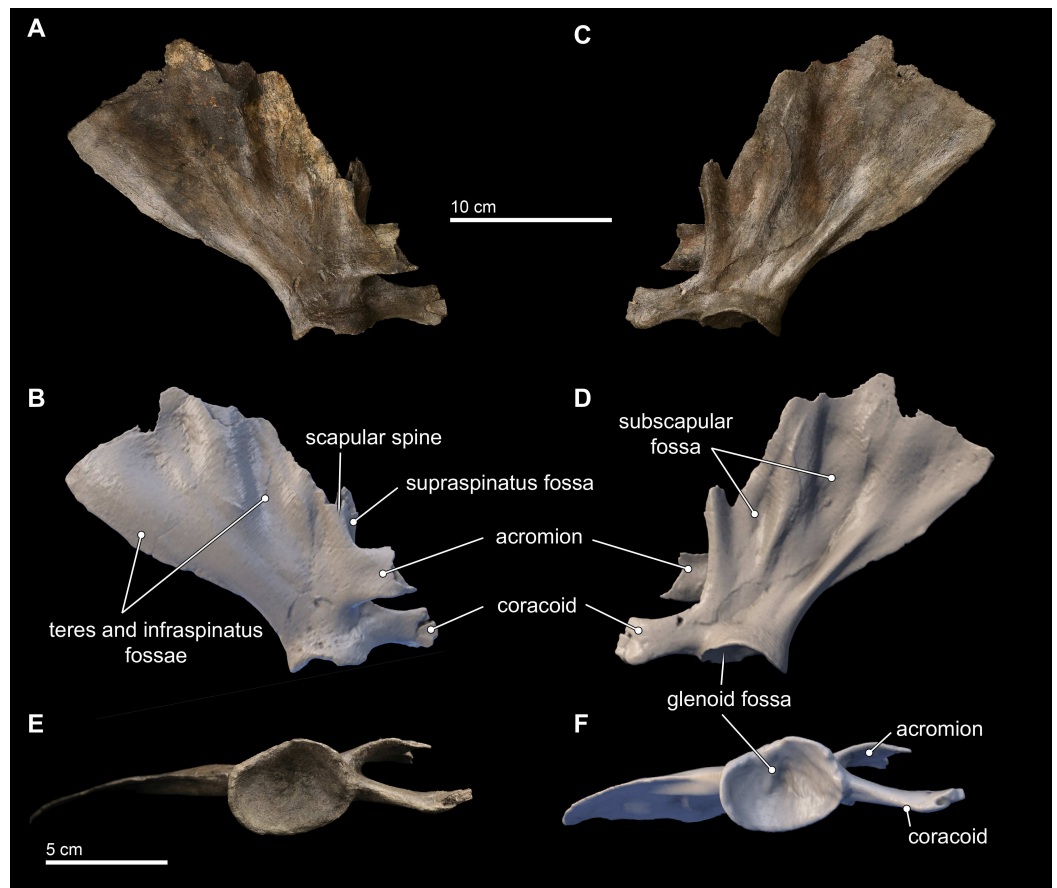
Scapula in lateral, medial, and distal views. Right scapula from *Isthminia panamensis* (USNM 546125) in lateral (A–B), medial (C–D), and distal (E–F) views. Each respective paired view shows photographs alongside orthogonal digital three-dimensional polygon model prepared from CT data, with lighting and color modifications using the Smithsonian X 3D browser. See <http://3d.si.edu/explorer?s=dmsTMI> (lateral view), <http://3d.si.edu/explorer?s=jPwTGO> (medial view), and <http://3d.si.edu/explorer?s=hwGm9I> (distal view). Anatomical terminology for the scapula follows *Tanaka & Fordyce (2015)* and *Uhen (2004)*.
